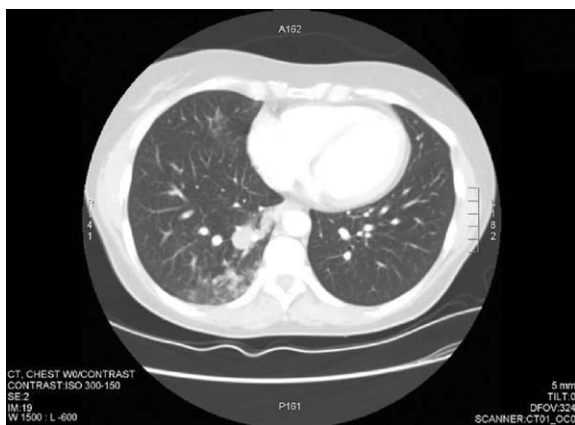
Case 1—CT (lung windows)—right posterior basal infiltrate and 2-cm mediastinal cyst.
